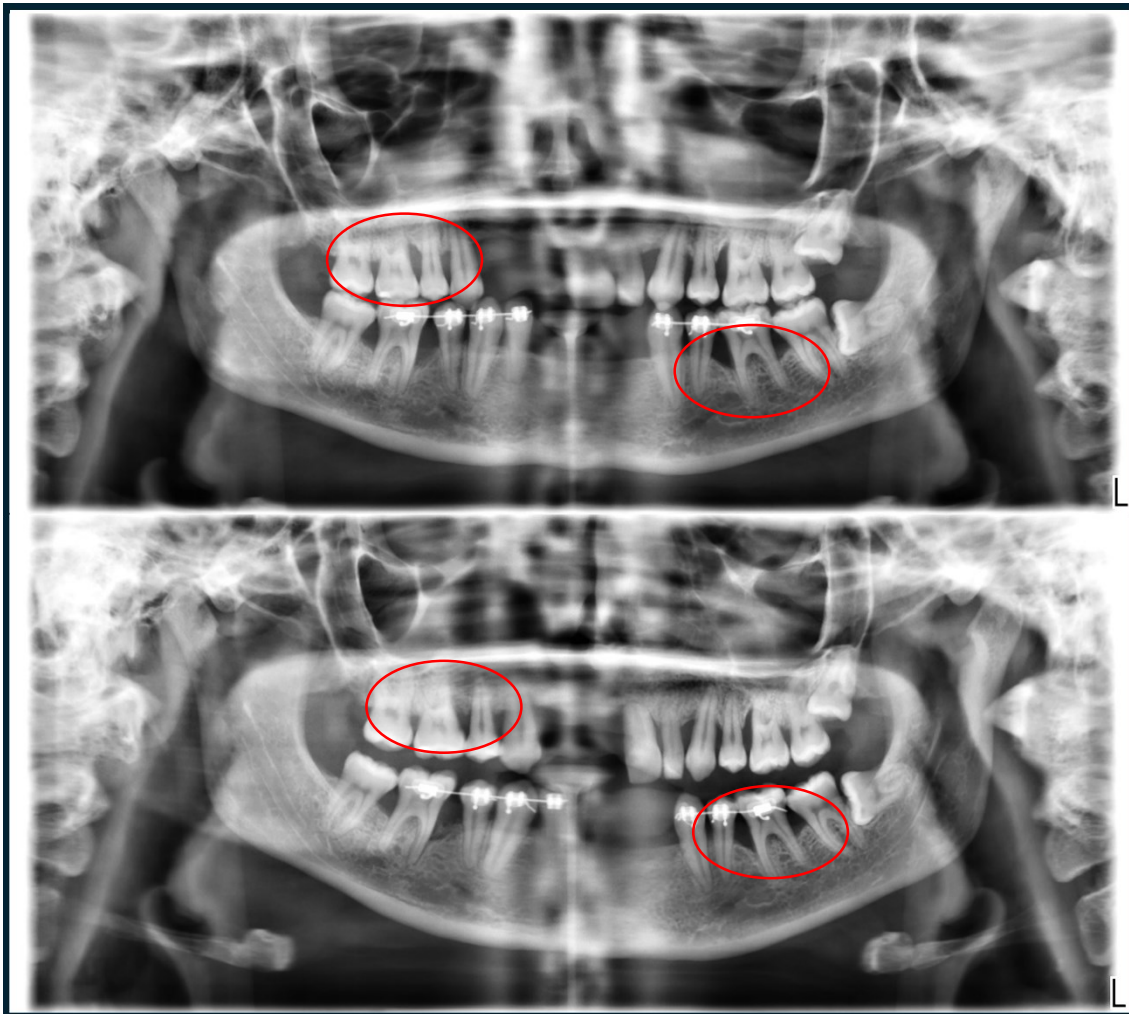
Patient SP11, orthopantomography comparison time 1 16/12/2023 (above), time 2 28/06/2024 (below)
